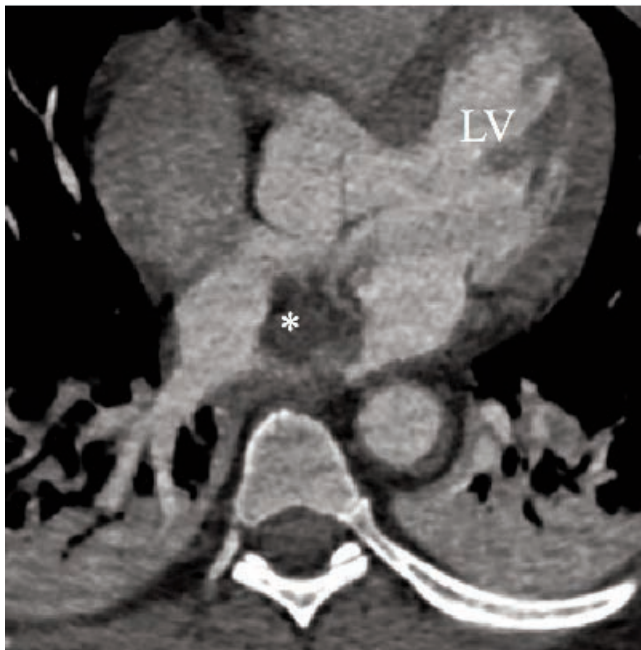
Cardiac CT scan showing a disomogeneous atrial mass. LV, left ventricle. The asterisk (\*) indicates myxoma.
